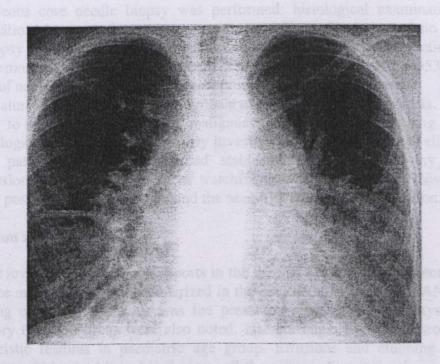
Chest X-ray showing mediastinal widening and bilateral interstitial infiltrates
